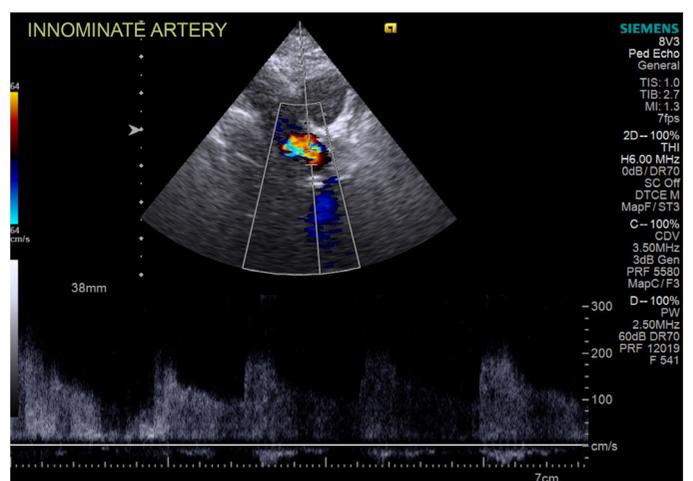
Significant increase in flow speed of the critical narrowing zone in spectral Doppler mode of the innominate artery
